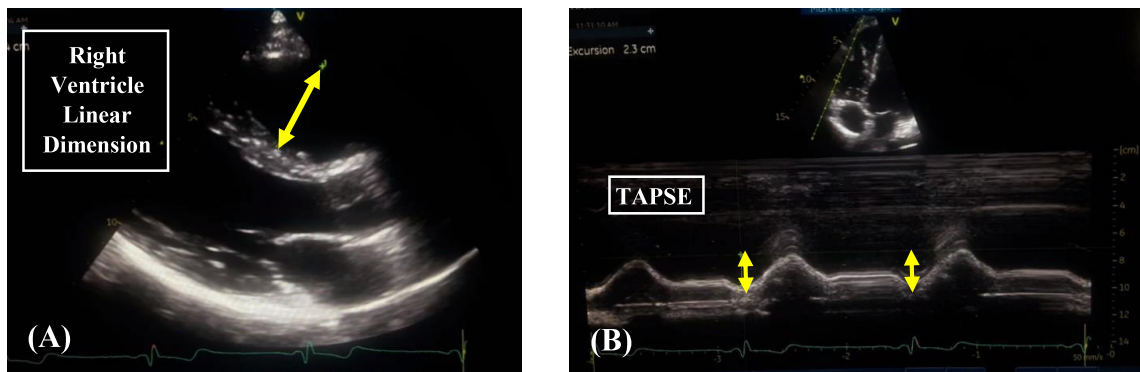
Echocardiographic Parameters. (A) Show the measurement of RV linear dimension (RVD) in PLAX view. (B) Shows the M-mode tracing of TAPSE, using the apical 4-chamber view.
